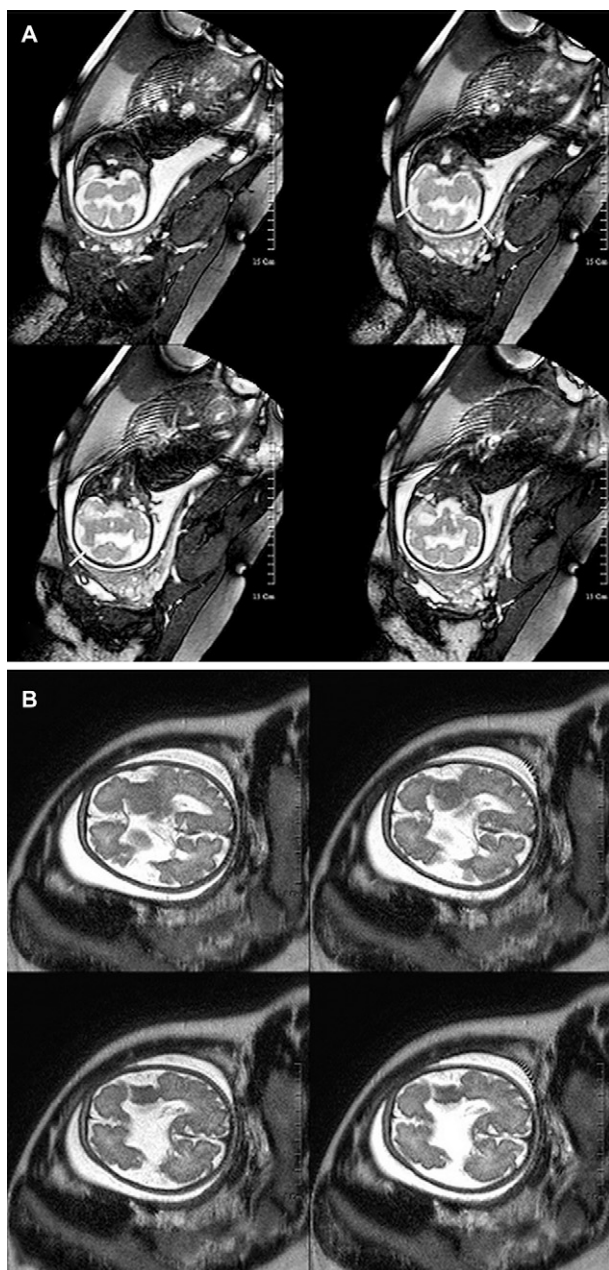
Fetal magnetic resonance imaging at 34 weeks gestation revealed brain clefts in both frontal lobes, with more on the left side. (A) Corpus callosum was preserved. No fat or subacute hematoma was visible and midline was centrally located. (B) Cystic dilatation at the temporal horn of the right lateral ventricle. The space-occupying lesion divided the fetal brain into two parts.
